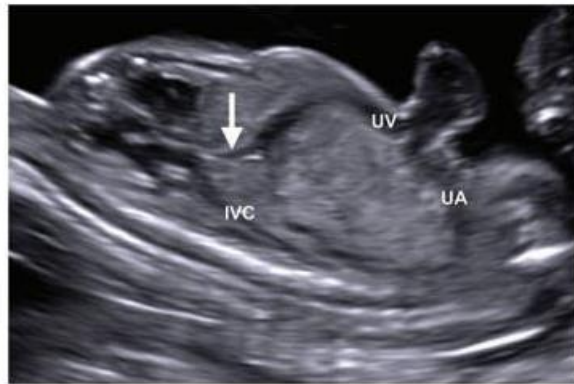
A. FETAL CIRCULATION, B. GRAY SCALE ULTRASOUND PARA-SAGGITAL VIEW, UV: UMBILICAL VEIN, UA: UMBILICAL ARTERY, DA: DUCTUS ARTERIOSUS, C: SLIGHT RIGHT PARA-SAGGITAL VIEW SHOWING DUCTUS VENOSUS IN WHITE ARROW CONNECTING UV AND INFERIOR VENA CAVA. [73]
